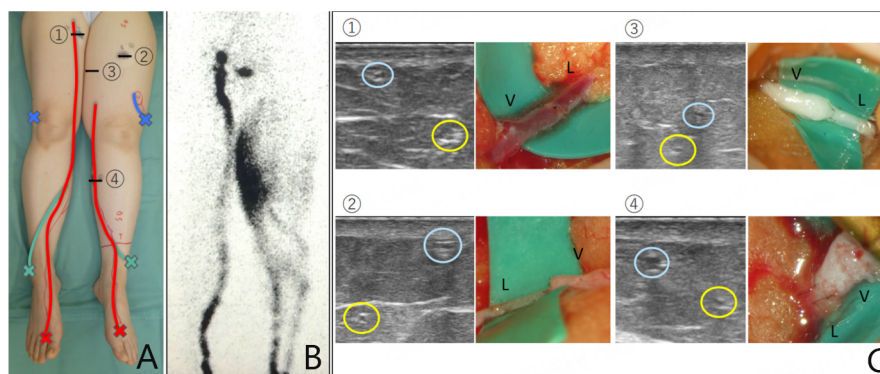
Case 1. A 52-year-old woman with secondary lymphedema in the legs. Black lines and numbers indicate skin incisions in lymphaticovenous anastomosis (LVA). (A) Clinical pictures and results of multi-point indocyanine green (ICG) lymphography. Cross marks indicate ICG injection sites; (B) Image of lymphoscintigraphy. Dermal backflow is observed in the left thigh. Additionally, slight dermal backflow is observed around the right inguinal lymph node; (C) Ultrasound findings and corresponding intraoperative findings during LVA. Blue circles indicate veins and yellow circles indicate lymph vessels. At each site, lymphatic vessels and veins consistent with ultrasonographic findings are observed. V: vein; L: lymphatic vessel.
